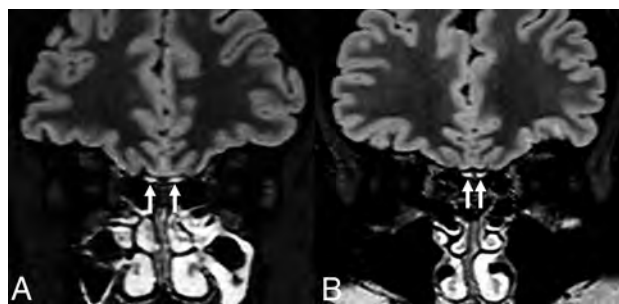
3T brain MR imaging in a healthy subject (A) and a patient with COVID-19–related anosmia (B). Coronal reformatted 3D FLAIR images show OB hyperintensity (arrows) compared with the cortex in both subjects.
